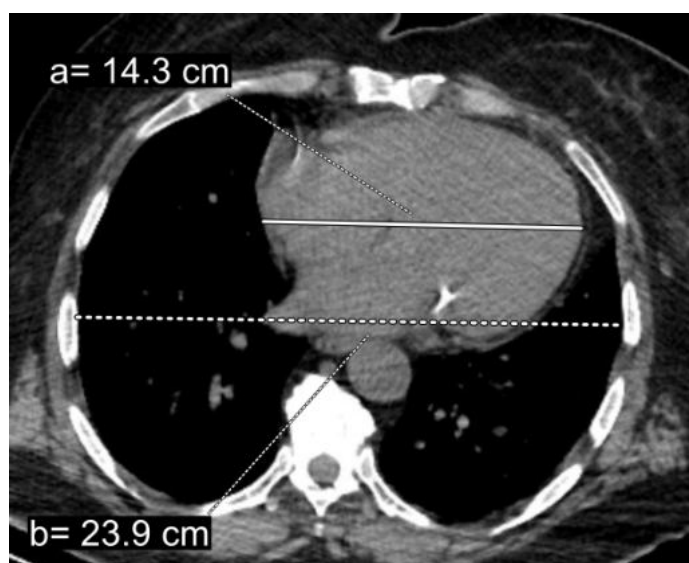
Axial image of chest CT shows the measurement of maximum transverse thoracic diameter (dashed line) and maximum transverse cardiac diameter (straight line) for calculating the cardiothoracic ratio. The cardiothoracic ratio was calculated as “0.60” by dividing the maximal diameter of the chest by the cardiac maximal diameter and there was cardiomegaly.
